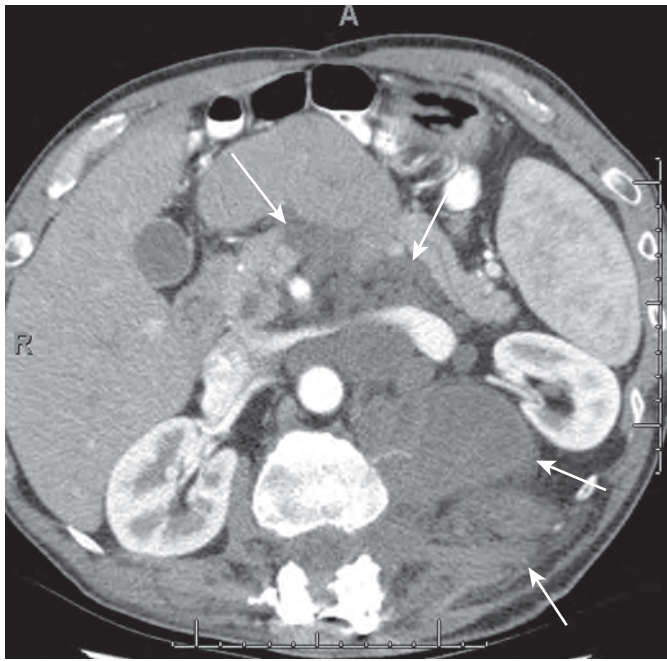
Neurofibroma. Axial CT demonstrating a low-attenuation, homogeneous mass involving the retroperitoneum and mesentery consistent with a neurofibroma (arrows).
